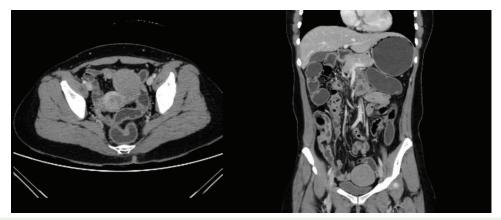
Axial and coronal view of computed tomography (CT) showing a 4.2×5.1 cm heterogeneous mass at the left adnexa.
